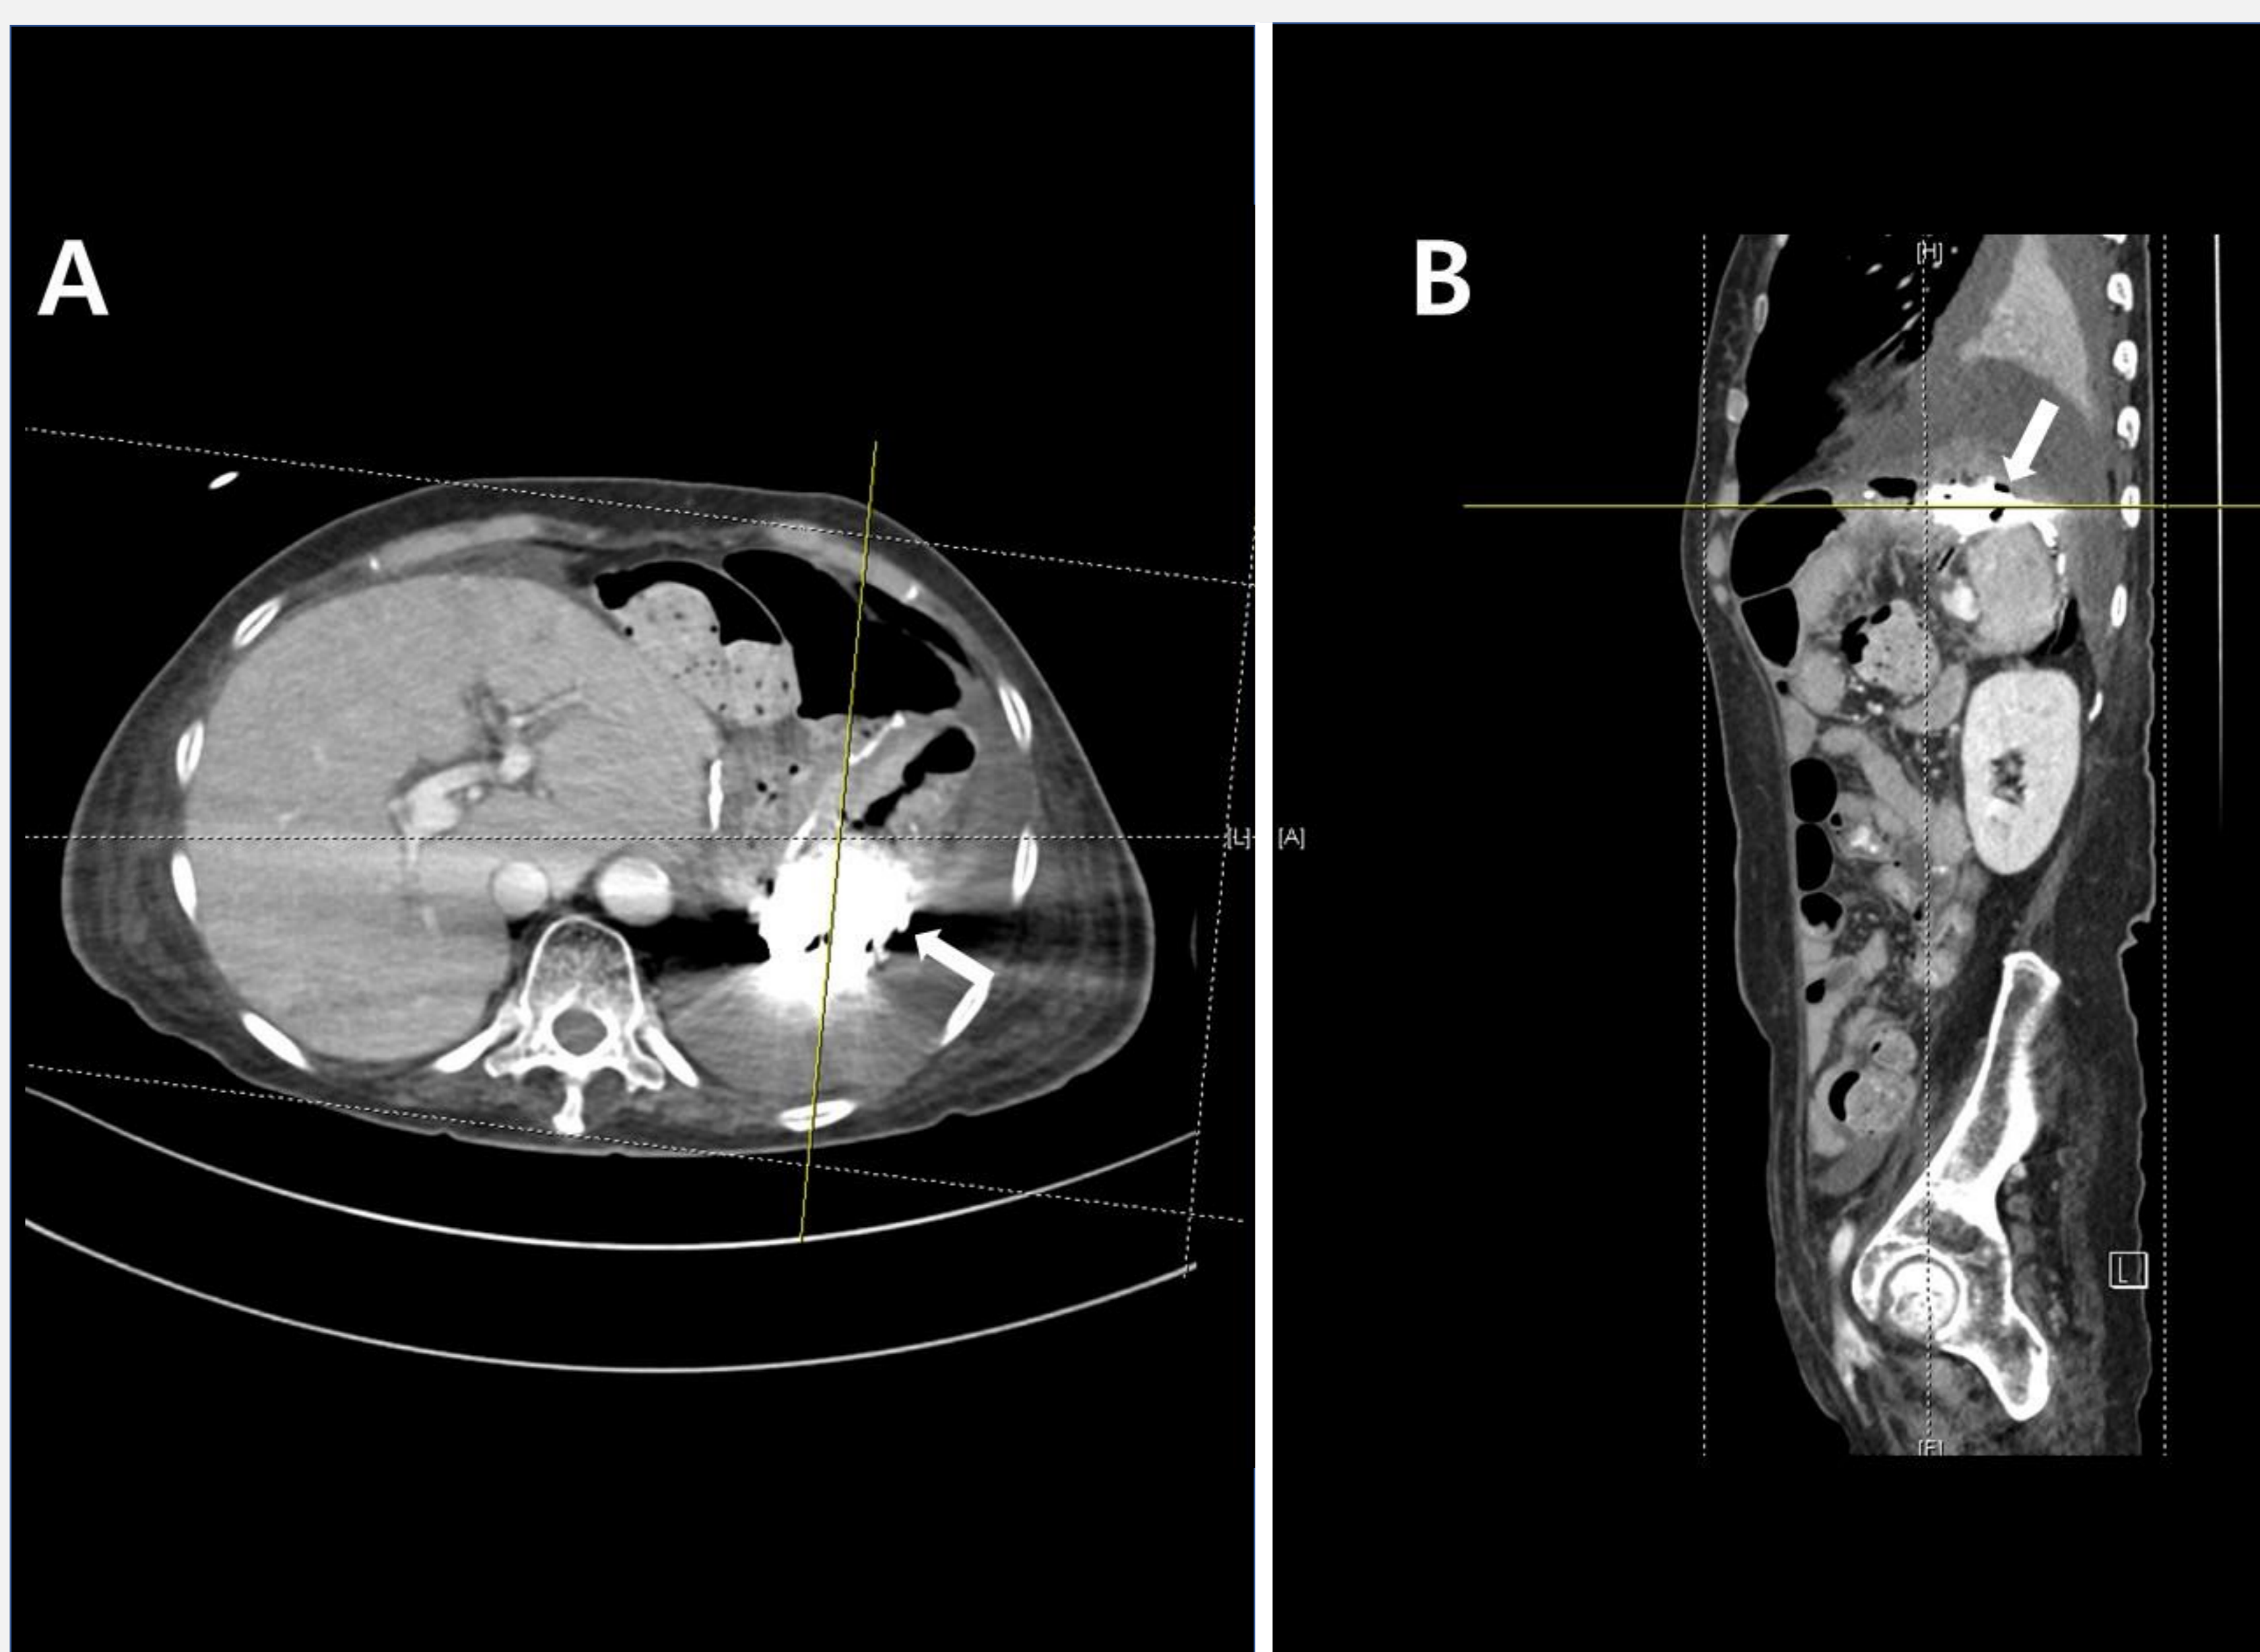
An abdominal CT image showing findings of gastric perforation. The contrast agent used for swallowing function evaluation is observed to have leaked into the peritoneal space through the perforation (white arrow). (A) axial and (B) sagittal images.
